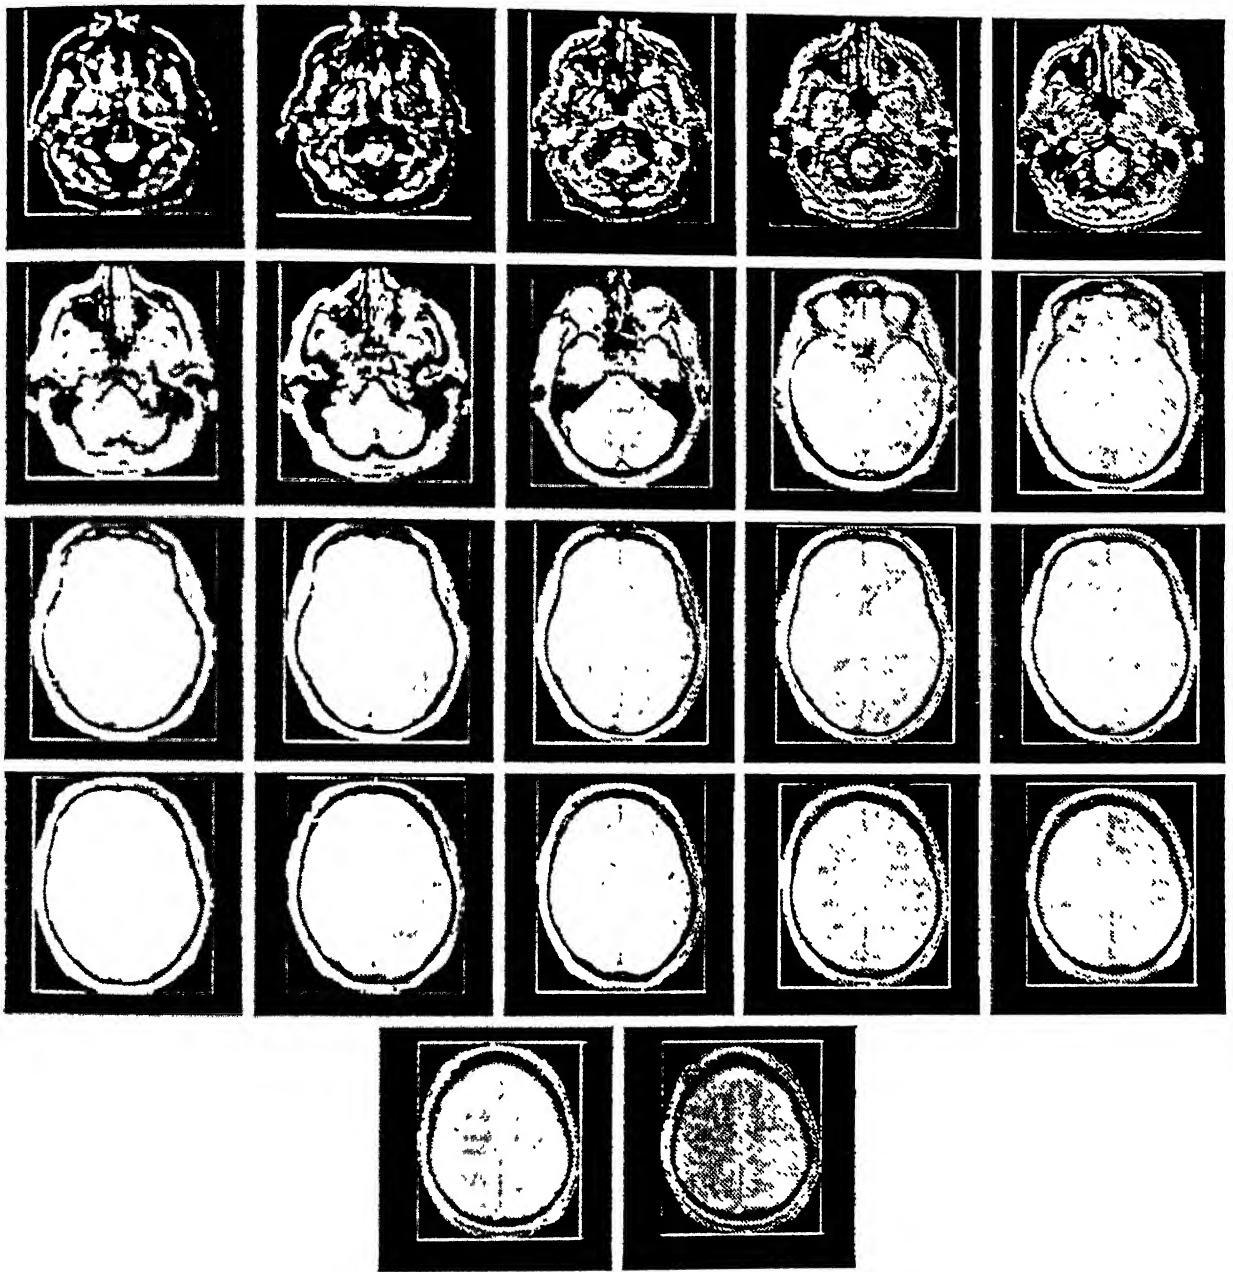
The Head Mask as well as the Head Bounding Box for MRI Data Set 1 overlaid on the PD-weighted scan
